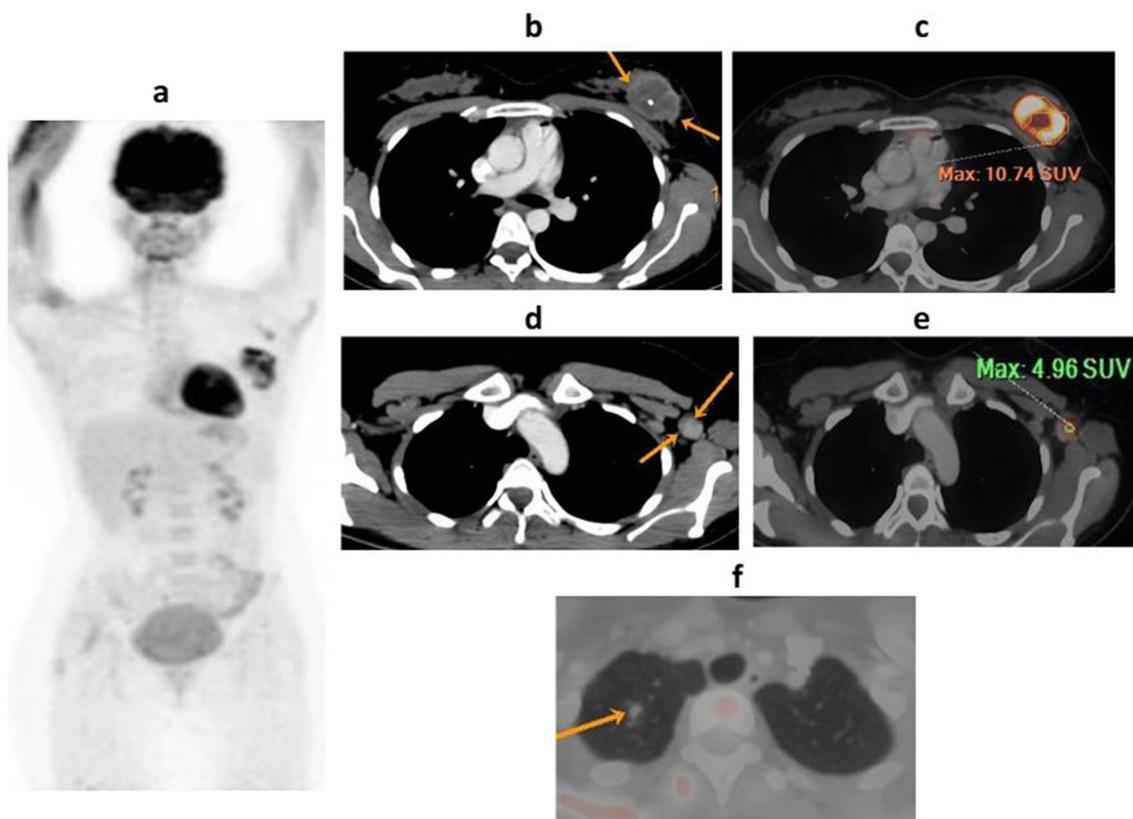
A 27-year-old female patient arrived with newly diagnosed left breast cancer (IDC grade II). a A whole-body PET MIP picture indicated active lesions in the left breast and axilla. b, c Axial CECT and fused PET/CT scans indicated an active heterogeneously enhancing soft tissue mass lesion in the upper outer quadrant of the left breast, with central inactive patches of necrosis and a minor calcific focus, measuring approximately 30 × 41 × 59 mm and attaining a maximum SUVmax of 10.74. d, e Axial CECT and fused PET/CT images revealed few left axillary and subpectoral lymph nodes, measuring up to 15 × 17 mm and achieving up to 4.96 SUVmax. f Axial fused PET/CT image revealed small non-FDG avid pulmonary nodule at the right lung apex, measuring 6 mm
